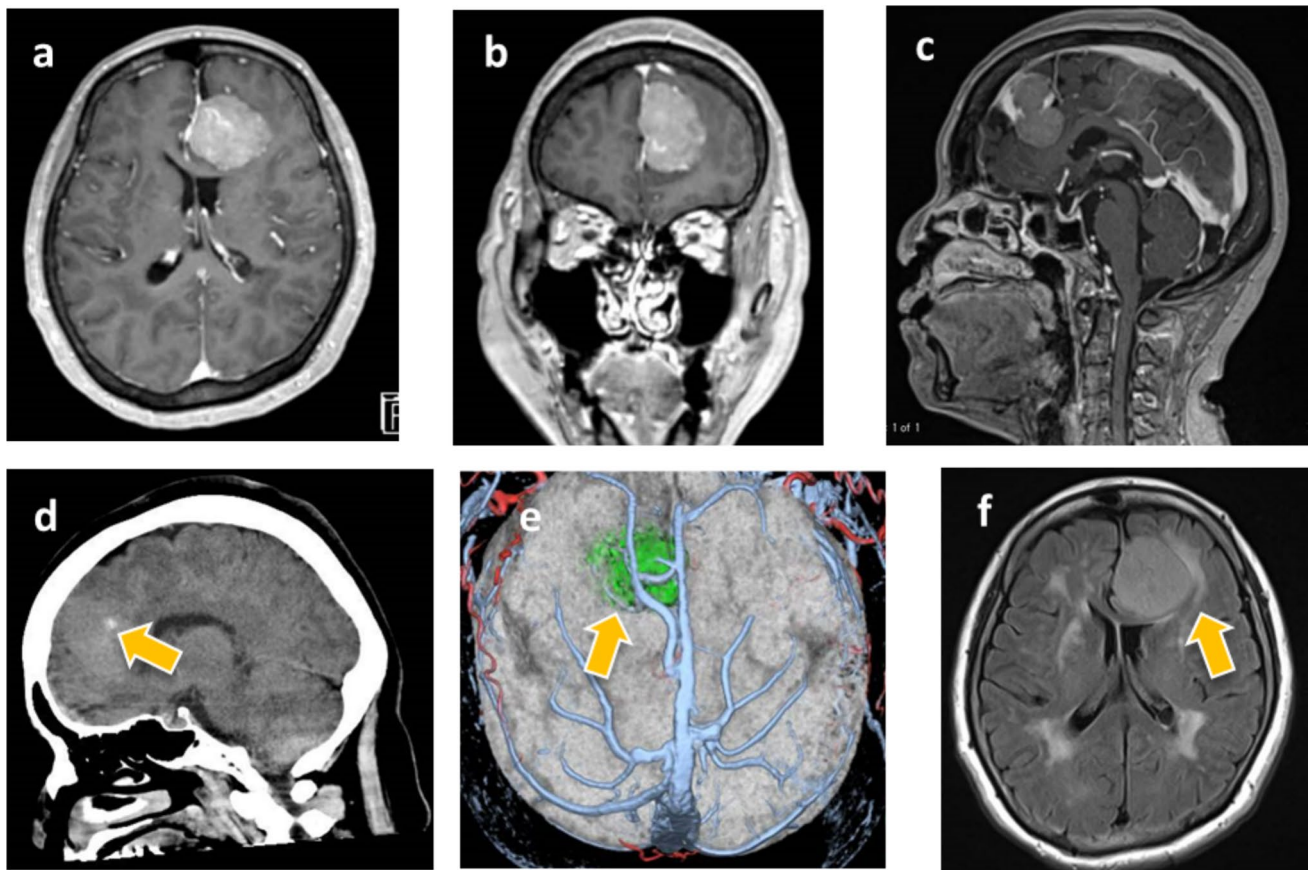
Contrast-enhanced MRI axial (a), coronal (b), and sagittal (c) images showed a homogeneous enhanced lesion with a maximum diameter of 35 mm attached at anterior part of the ipsilateral falx. Preoperative CT showed calcified lesions (d), 3D fusion image which
